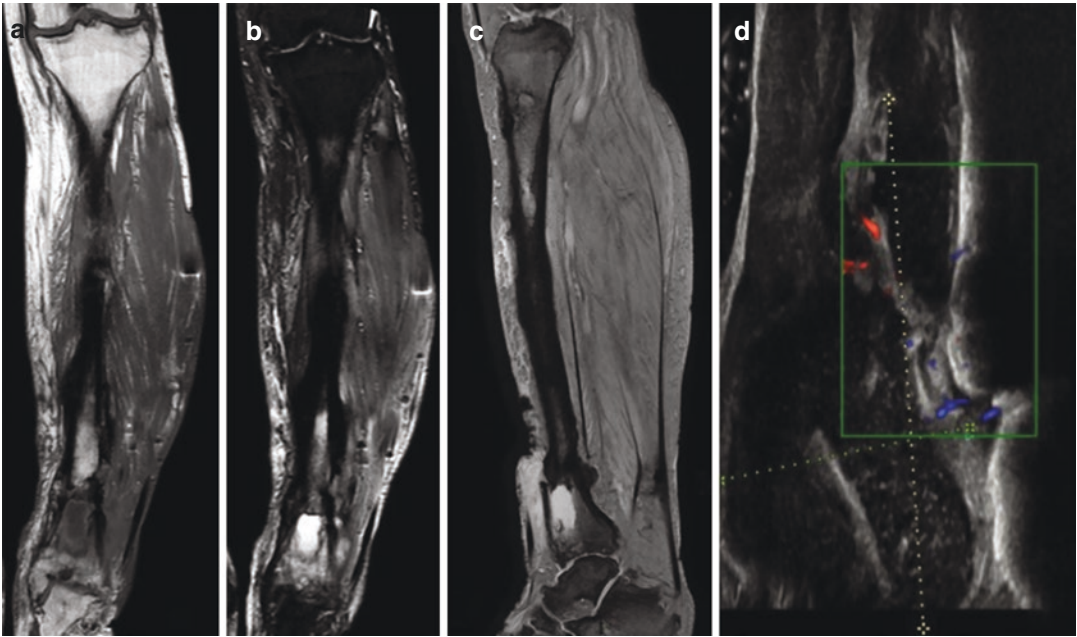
Reactivated chronic osteomyelitis. (a–c) MRI T1w and STIR coronal sequences and GRE T2*w sagittal sequence of left tibia show signs of chronic osteomyelitis with widening of the diaphysis, cortical thickening, and irregular periosteal reaction. Multiple central medullary lesions consistent with sequestrum are also visible. (c, d) GRE T2*w sagittal
